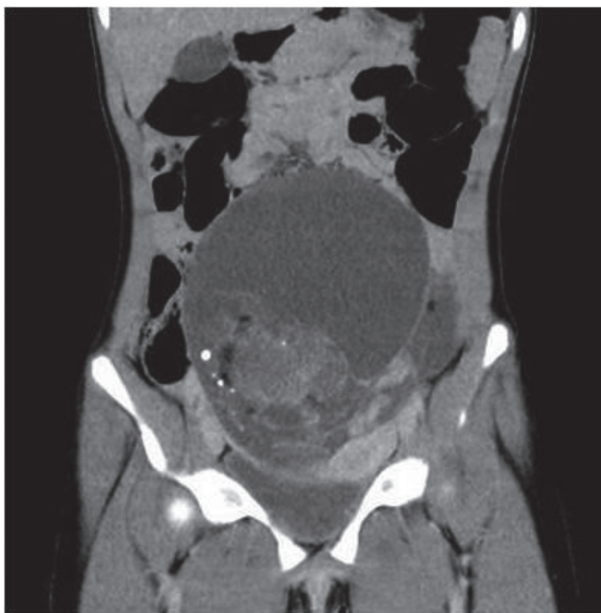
CT scan (sagittal section) showing a large pelvic mass, measuring 20 x 14 x 9 cm, with fatty components and some hyperdense calcific areas
